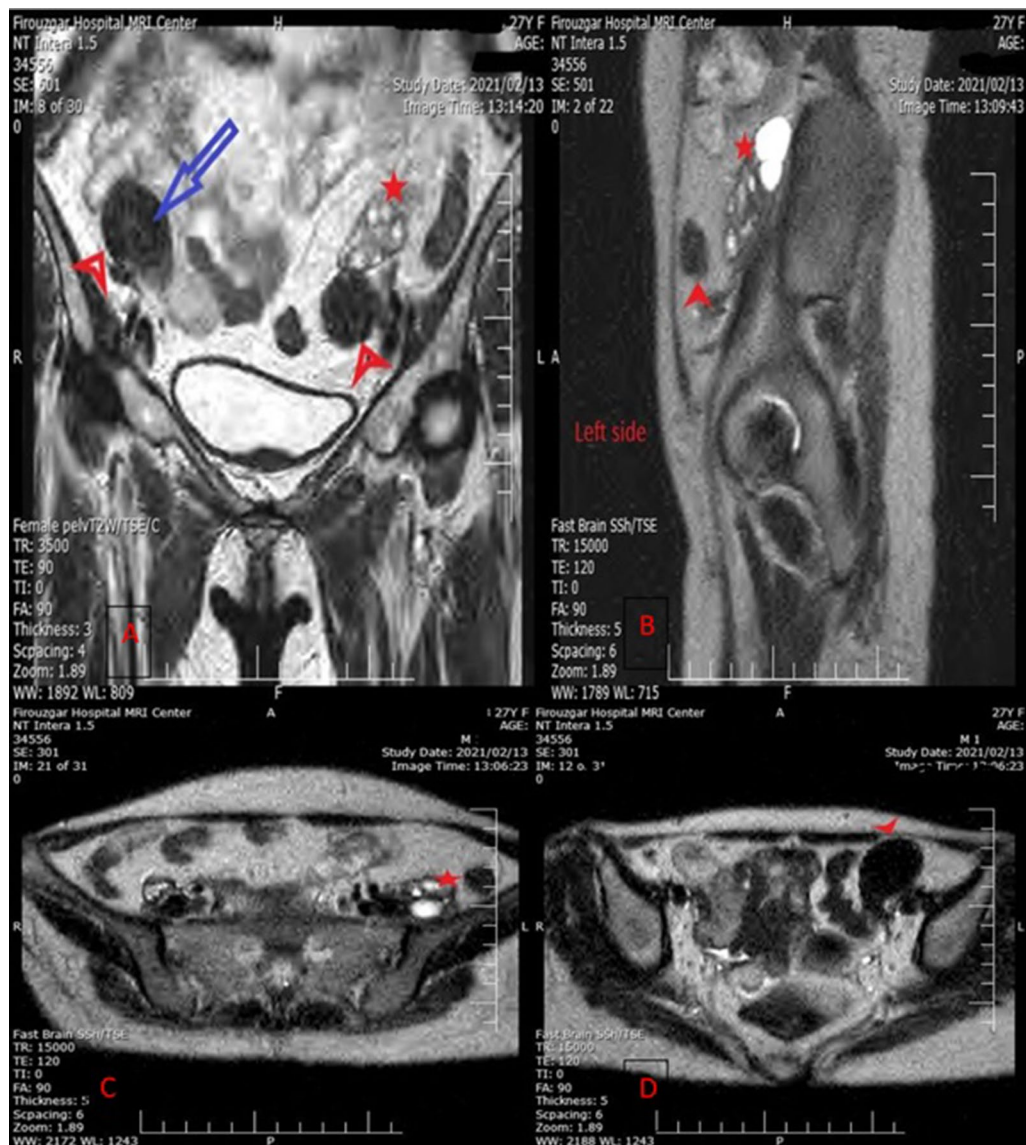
Coronal and sagittal T2-weighted images in (a, b) show retroperitoneal low signal structure (red arrow head) under left iliac artery bifurcation, in favor of completely separate uterus with separate hypoplastic cervix, Coronal, sagittal and axial T2-weighted images in (a–c) show retroperitoneal structure with a few intralesional cystic components with morphology similar to left ovary (*) in pelvic inlet level, d left horn of didelphys uterus is shown in axial view (red arrow head)
